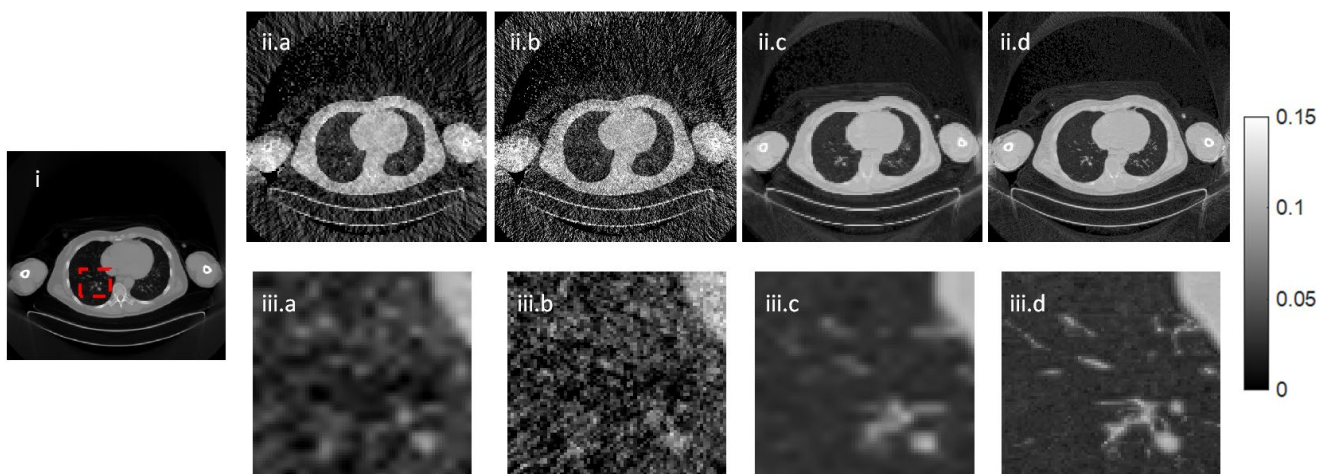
Results of patient data for (i) 80 kVp x-ray CT image, the red box indicates the region for zoomed-in views, (ii) gCT images and (iii) zoomed-in views of the gCT images reconstructed with (a) MLAA at the PET resolution, (b) MLAA at the CT resolution, (c) kMLAA at the PET resolution, and (d) kMLAA at the CT resolution.
